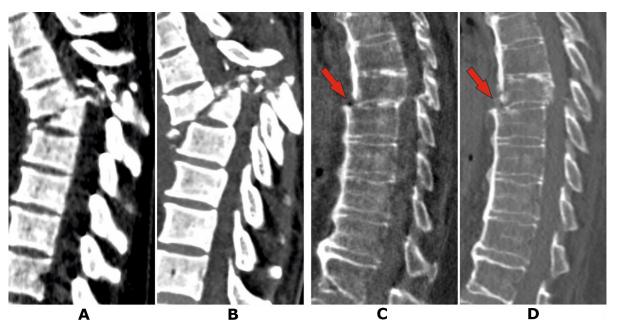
Patient P., 37 years old. CT scans of the thoracic spine: A – on the day of the injury; B – after 5 weeks. Patient V., 58 years old: C – 2 days post-injury; D – after 2 months (details in the text)
